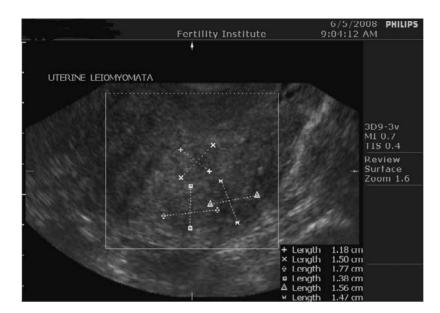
Three-dimensional ultrasound image of uterus with multiple leiomyomata, one of which intrudes into the uterine cavity, with another in position to obstruct the cornu.
